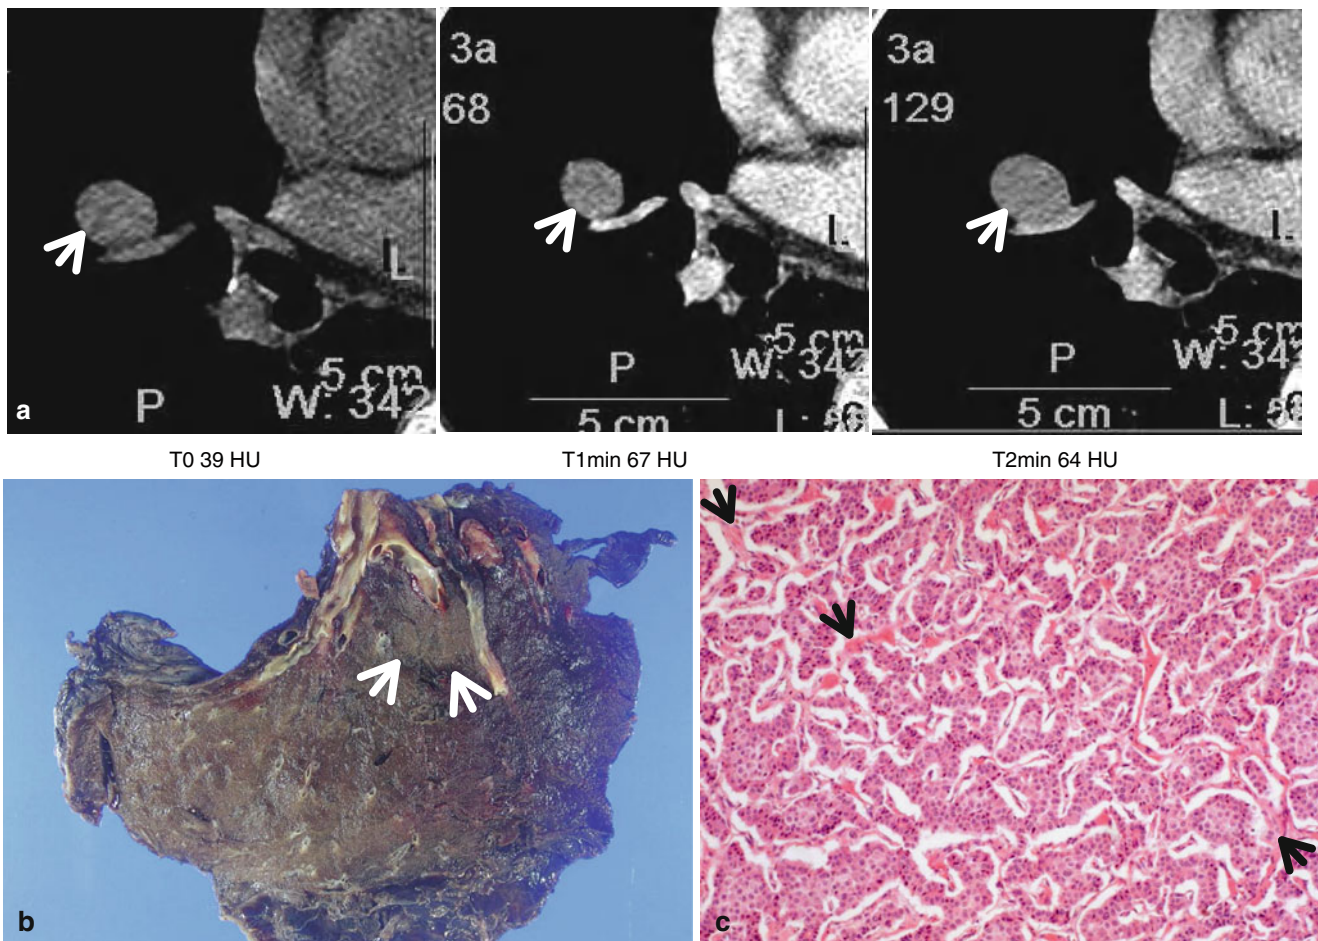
Typical carcinoid tumor showing high and early enhancement in a 58-year-old man. (a) Dynamic CT scans obtained at level of right middle lobar bronchus takeoff show an 18-mm-sized well-defined nodule (arrows) in the right middle lobe. Nodule depicts high enhancement (39 HU, 67 HU, and 64 HU; before, at 1 min, and at 2 min after contrast-medium injection, respectively). (b) Gross pathologic
